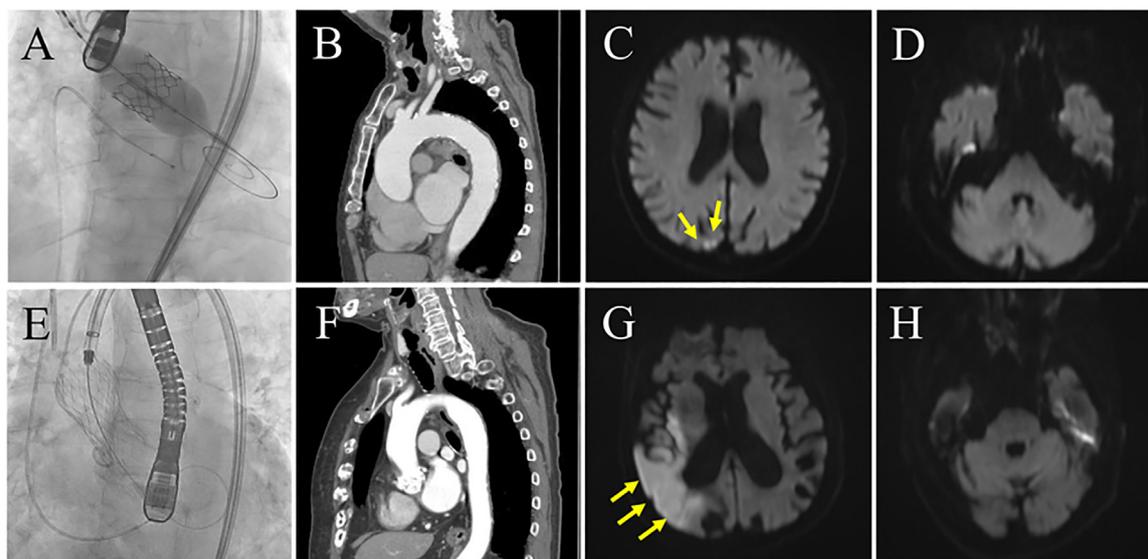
Representative cases. Cases of cerebral infarction after insertion of a 26 mm-sized balloon-expandable Sapien 3 (A–D) and 26-mm sized self-expandable CoreValve (E–H) transfemoral TAVR. (A) and (E) represent cineradiography during TAVR, (B) and (F) reveal pre-procedural enhanced-CT evaluating the aortic arch in the sagittal view, (C) and (G) post-procedural DWI of cerebrum, and (D) and (H) demonstrated post-procedural DWI of cerebellum. Yellow arrows indicate high-intensity area suggesting two spotty infarctions in image (C) and one massive infarction in image (G).
